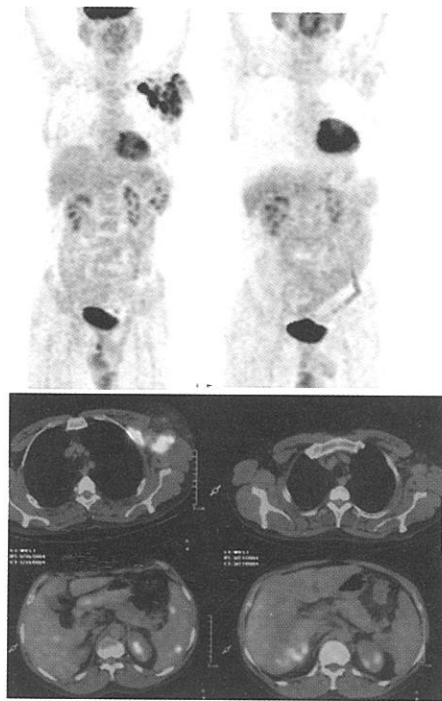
A case of Non-Hodgkin's Lymphoma with disease in axilla; showing complete metabolic response, when evaluated with FDG-PET/CT after 3 cycles of chemotherapy.
